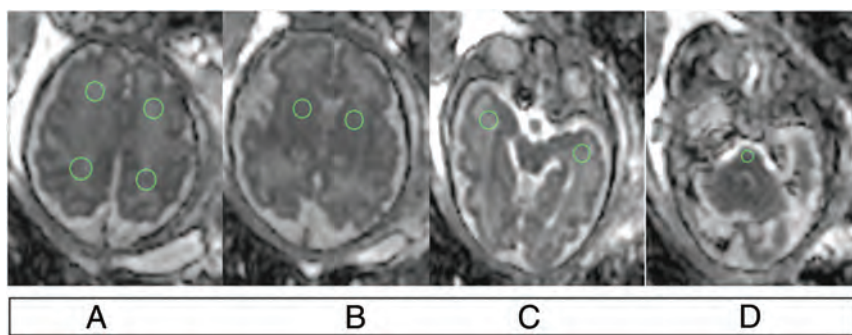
ROI placement on ADC map of DWI. A, Frontal and parietal lobes. B, Basal ganglia. C, Temporal lobes. D, Pons.
